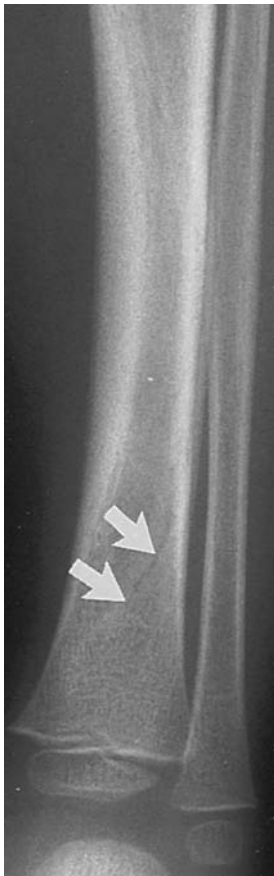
Toddler's fracture of the distal tibia (*arrows*). The fracture line could not be demonstrated radiographically until 2 weeks after the onset of symptoms.
